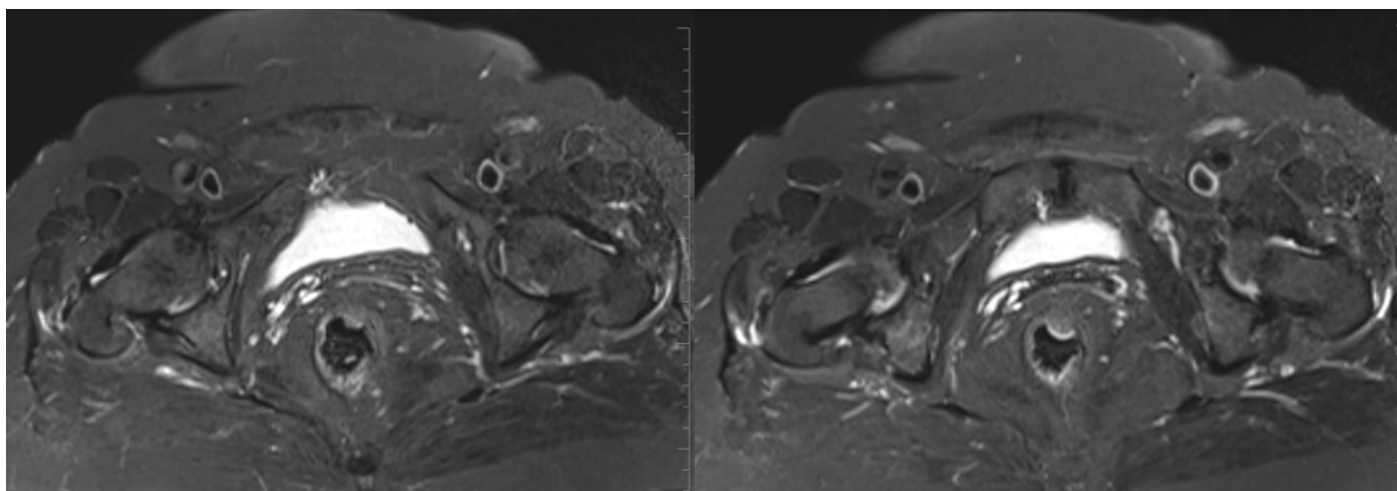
Axial T2-weighted sequences showing localized thickening of the posterior/lateral quadrant of the rectal wall. Signal intensity is pronounced at the submucosal level, with no significant infiltration into the surrounding fatty tissue. No diffuse inflammatory reaction or fistulous tract is observed. The mesorectal fat plane is preserved, and no significant perirectal pathological lymphadenopathy is noted.
